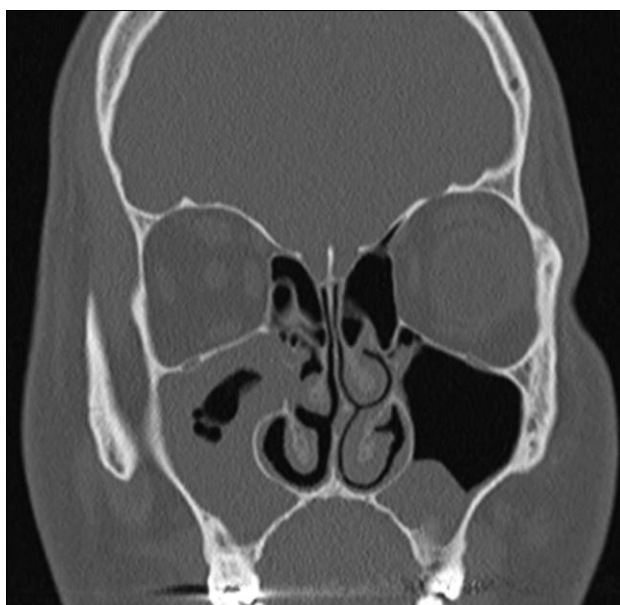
Coronal CT section showing bilateral maxillary sinusitis.
